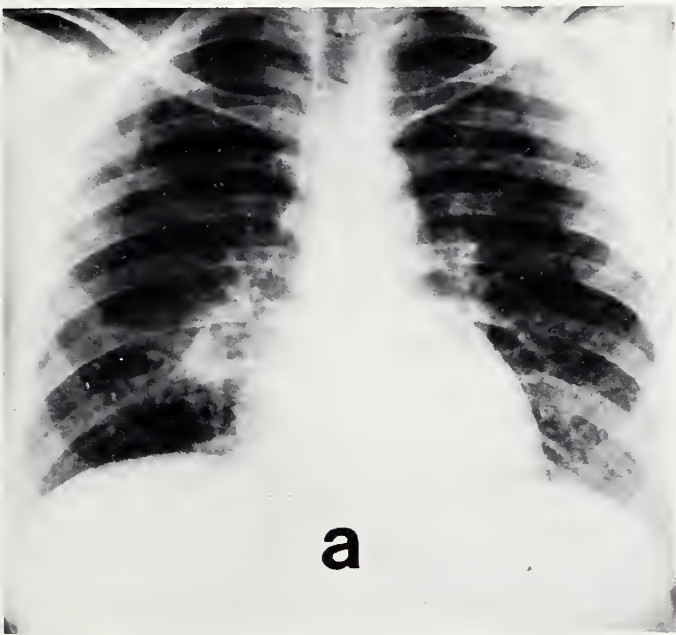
Chest x-ray on admission (a) revealed apparently clear lung fields; six days later (b), a diffuse, finely-nodular infiltrate was evident.
